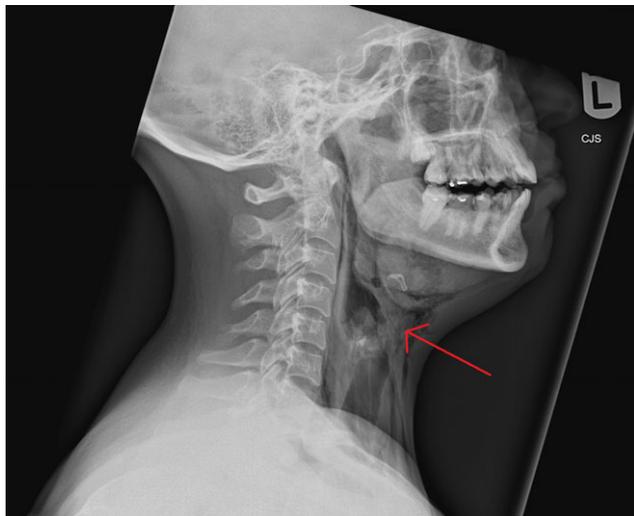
Head and neck plain film X-ray showing air in the soft tissues of the neck.
